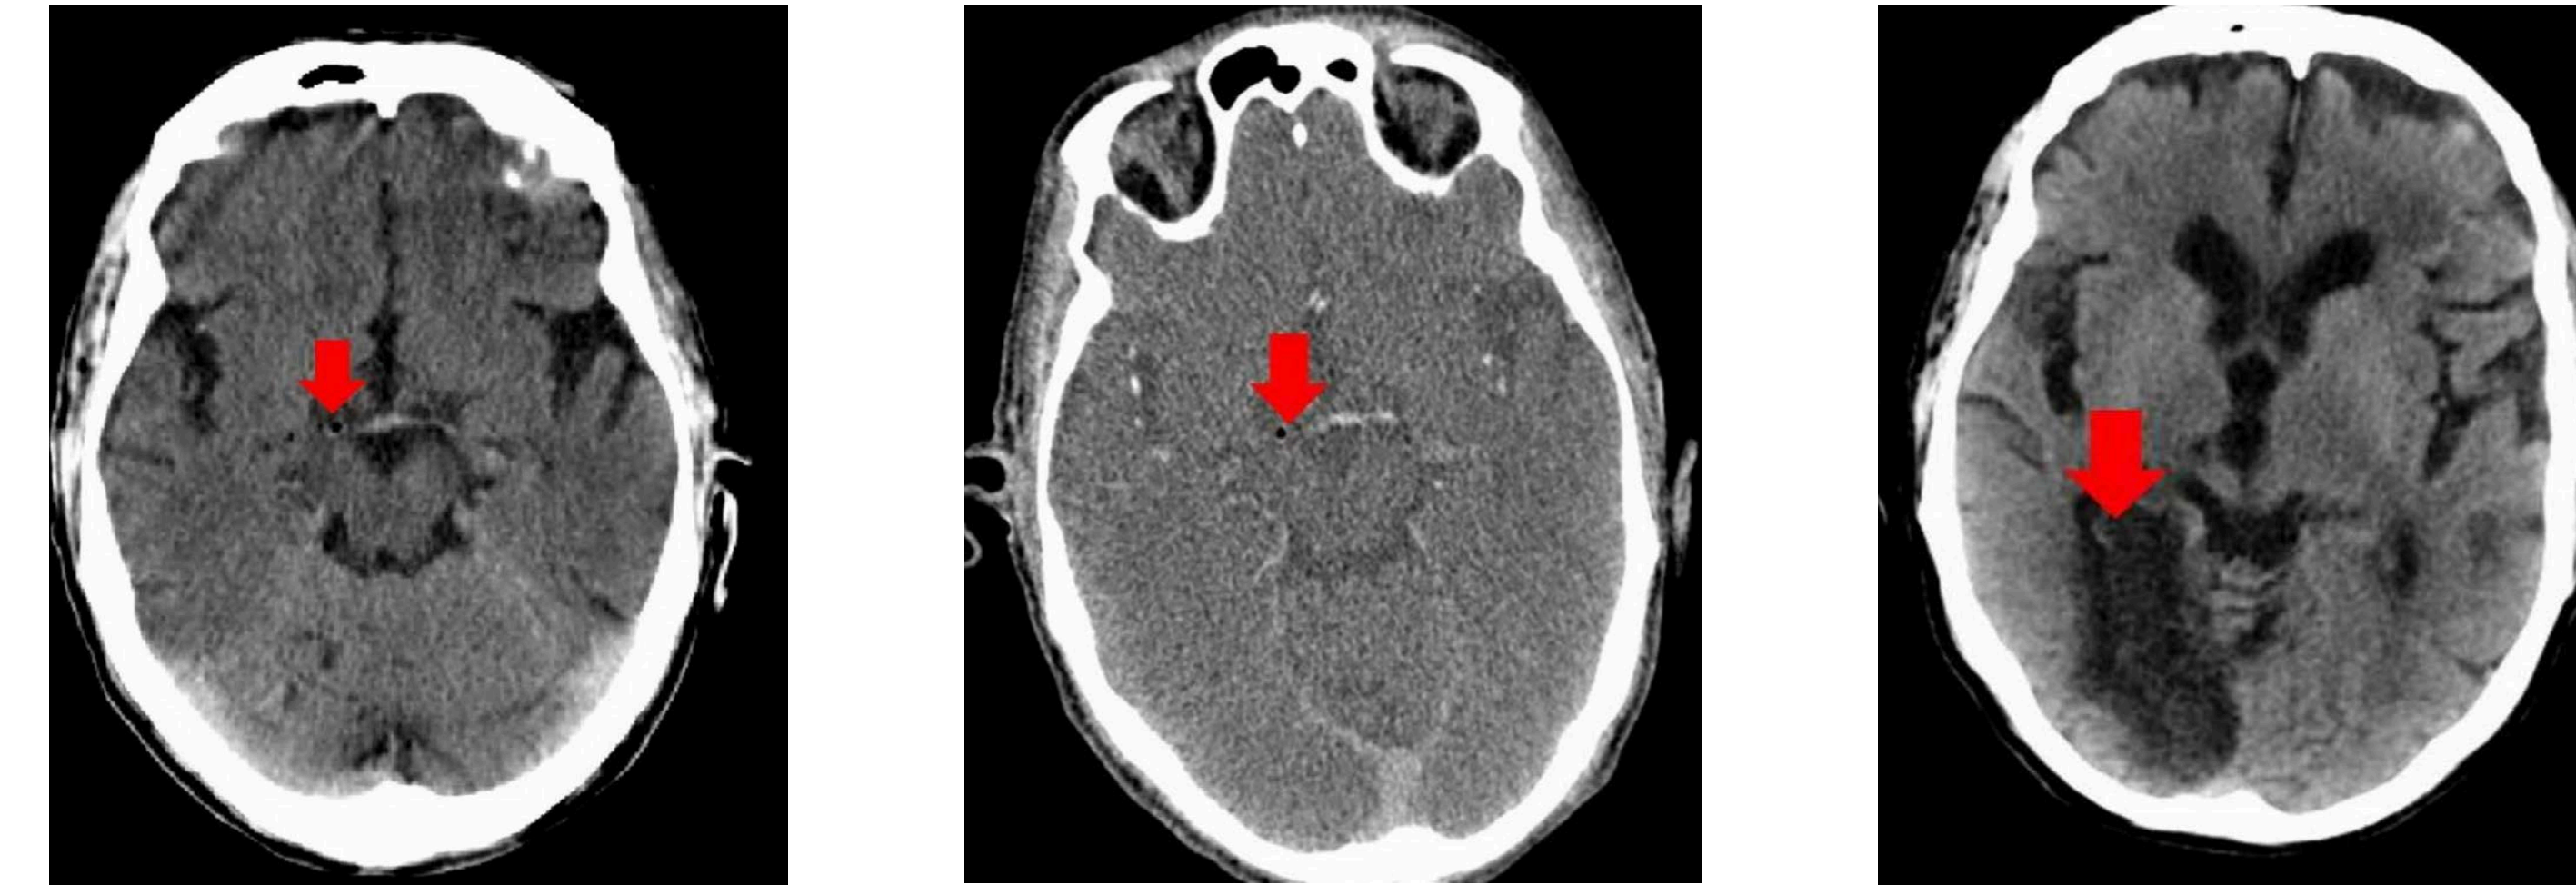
Initial imaging revealed no thrombus but an air embolus in the right P2 division of the posterior cerebral artery which was more clearly visible on CT angiography.
